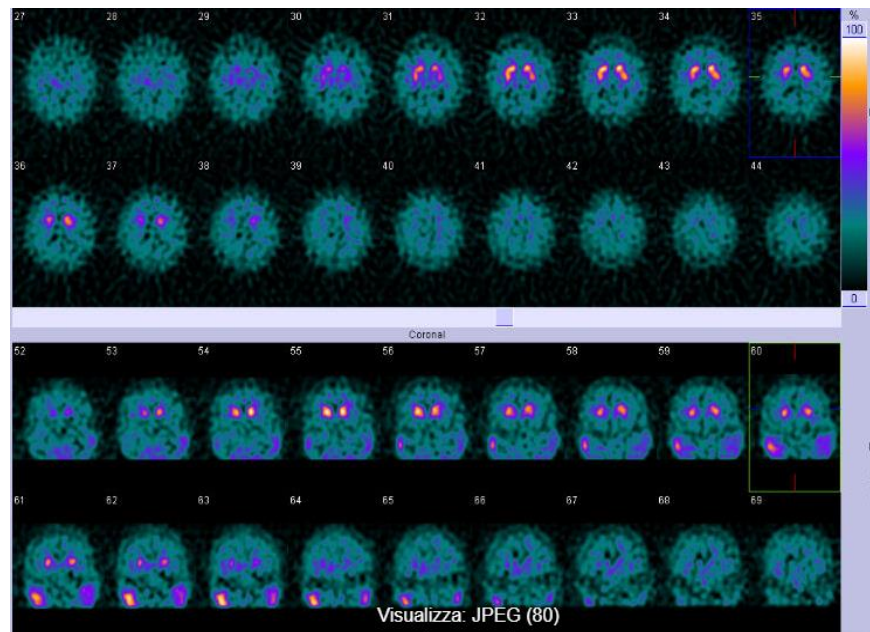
SPECT DAT SCAN negative in first patient.
